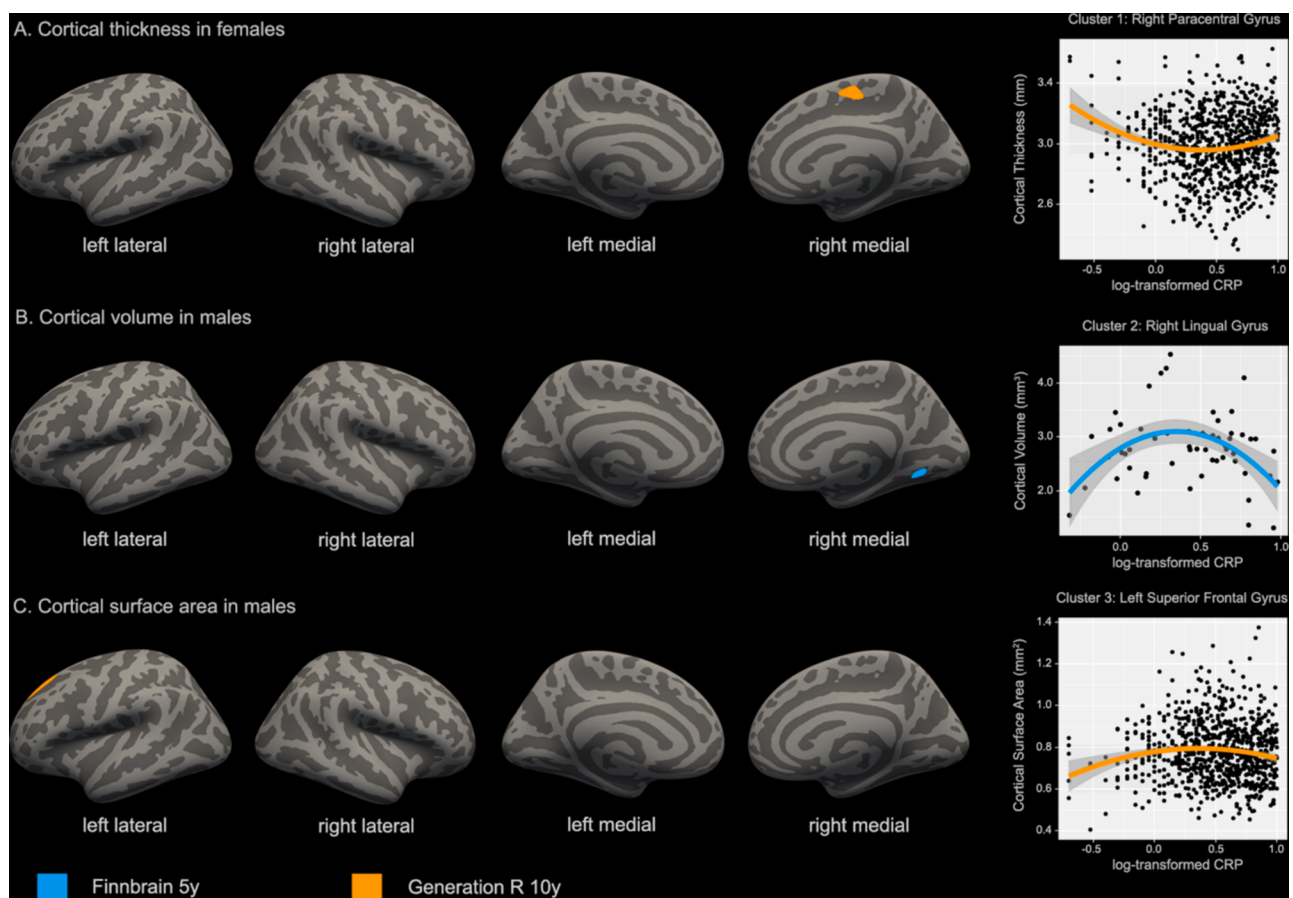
Cortical clusters associated with physiological prenatal maternal CRP (<10 mg/L) in the population-based cohorts. Associations between offspring cortical morphology (cortical thickness, cortical volume, surface area) and prenatal maternal CRP (<10 mg/L) in vertex-wise quadratic regression in the population-based cohorts. The model was adjusted for participant age at MR imaging, gestational week of CRP measurement, maternal smoking, alcohol use, pre-pregnancy BMI, age, and education. CRP was measured from serum samples collected during the first or second trimester of pregnancy. Panel A represents cortical thickness in females, panel B represents cortical volume in males, and panel C represents cortical surface area in males. Colours represent different cohorts.
